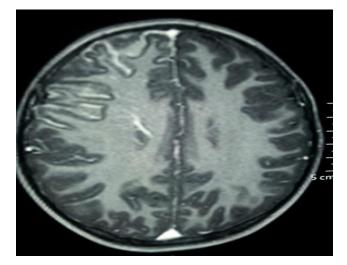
MRI Brain Axial image showing multiple medullary flow voids in deep mater of right frontoparietal areas draining into transcortical vein.
